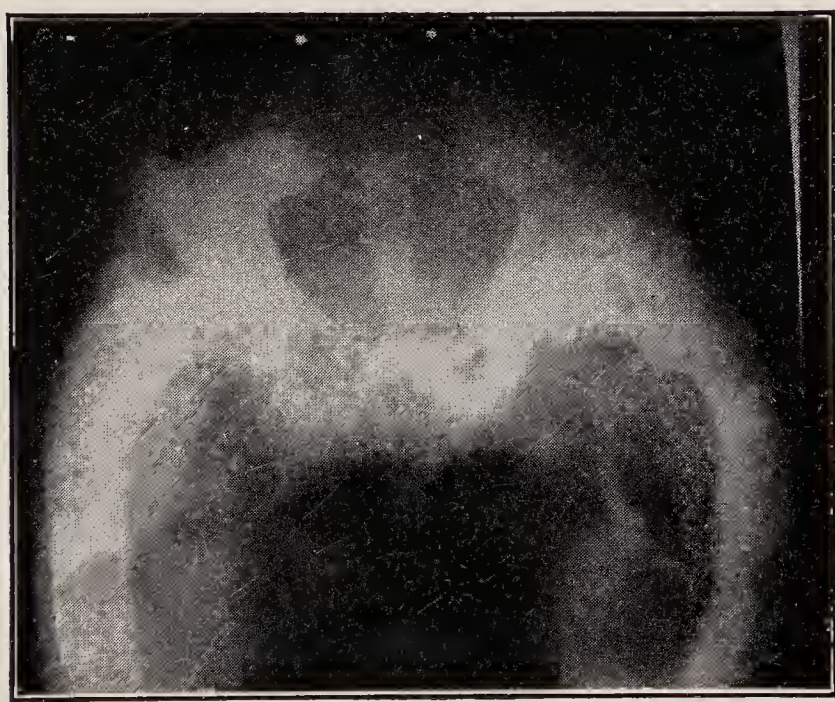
X-ray of ostitis fibrosa of pelvis and femora (same case as Fig. 358).
